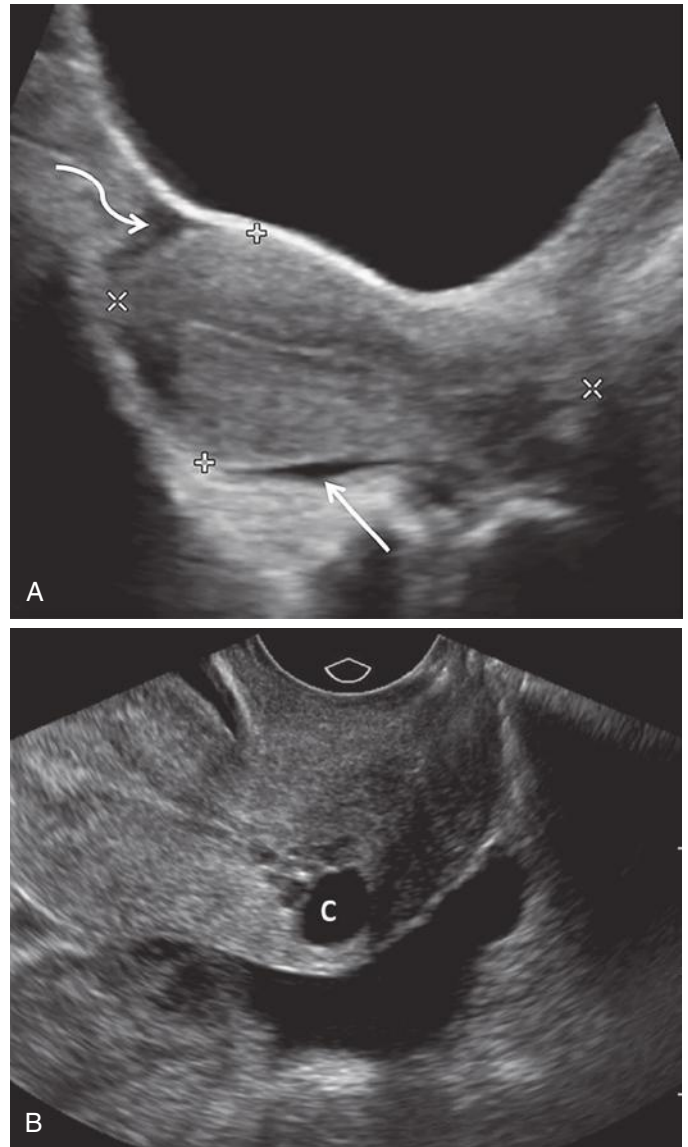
Free pelvic fluid. A, Longitudinal transabdominal sonogram of the uterus (*calipers*) shows a small amount of fluid in the anterior (*curved arrow*) and posterior cul-de-sac (*straight arrow*). B, Longitudinal transvaginal scan in a different patient shows anterior and posterior cul-de-sac free fluid. A nabothian cyst (C) is visible in the cervix.
